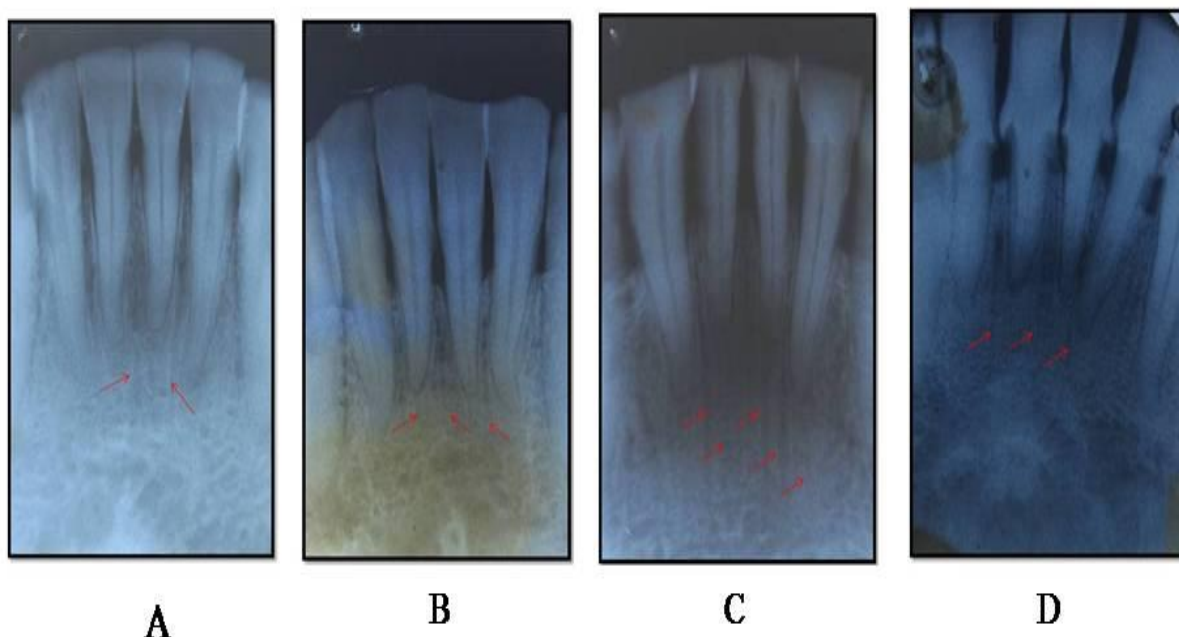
A to D. Intraoral periapical radiograph showing nutrient canals in (A) Normal individual (B) Person having periodontitis (C) Person having hypertension (D) Person having Diabetes
